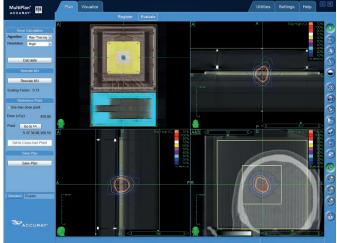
Same Patient QA plan as in Figure 2 but with the patient CT
